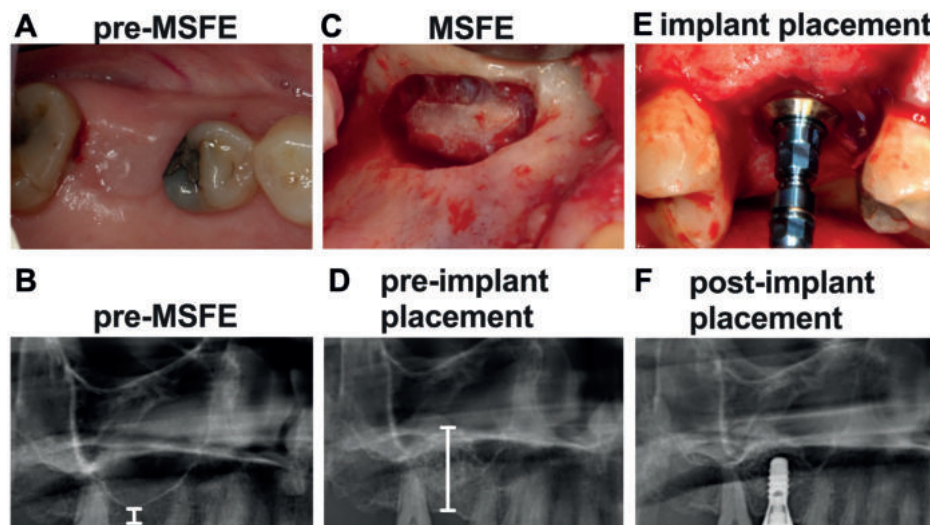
Clinical photographs of MSFE via a lateral approach allowing dental implant placement, and their corresponding radiographs to evaluate maxillary sinus and alveolar bone height. (A) Preoperative photograph of the clinical situation. (B) Preoperative radiograph of the maxillary sinus. White line: residual native bone height. (C) Photograph of the lateral window during MSFE. (D) Radiograph of the maxillary sinus 4-months post-MSFE prior to implant placement. White line: total bone height. (E) Photograph of implant placement at 4-months post-MSFE. (F) Radiograph of the maxillary sinus directly after implant placement.
